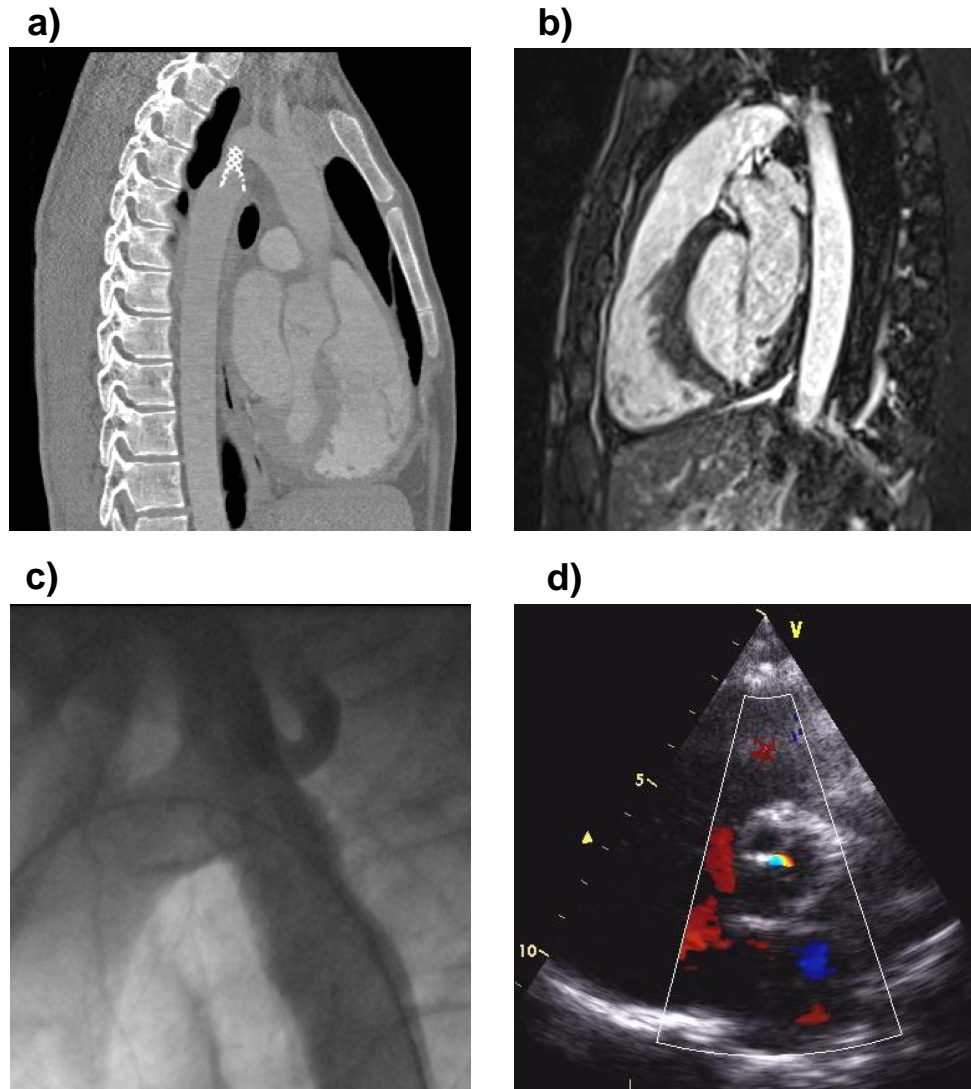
Imaging data available to set-up the computational model: a) CT, b) MR, c) fluoroscopy, and d) echo data.
